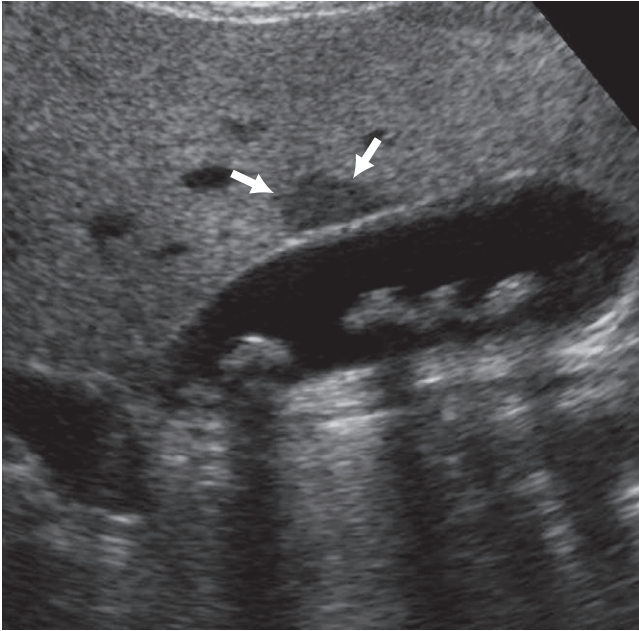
Longitudinal real-time ultrasound examination of the liver and gallbladder demonstrates presence of cholelithiasis and a hypoechoic region (arrows) adjacent to the gallbladder in an otherwise echogenic liver.
